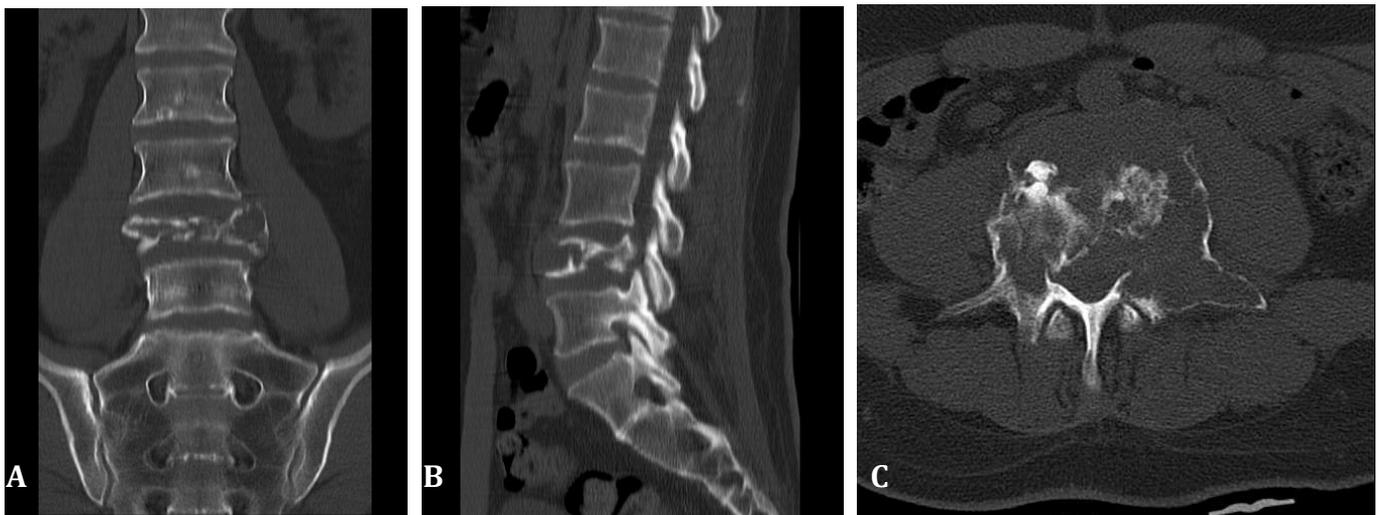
Computed tomography scan of solitary plasmacytoma of bone in L4 vertebra. A) Coronal imaging showing expansile, irregular osteolytic lesion. B) Sagittal imaging showing significant collapse and instability. C) Axial imaging showing anterior, middle and posterior element involvement and mild canal compromise, specially on the left side.
